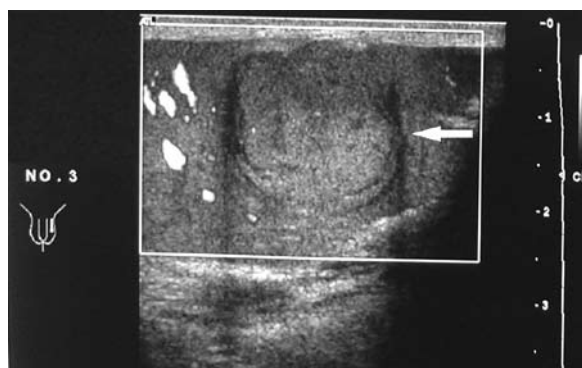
Color Doppler image of left testicle showing lack of vascularity in the isoechoic lesion.
